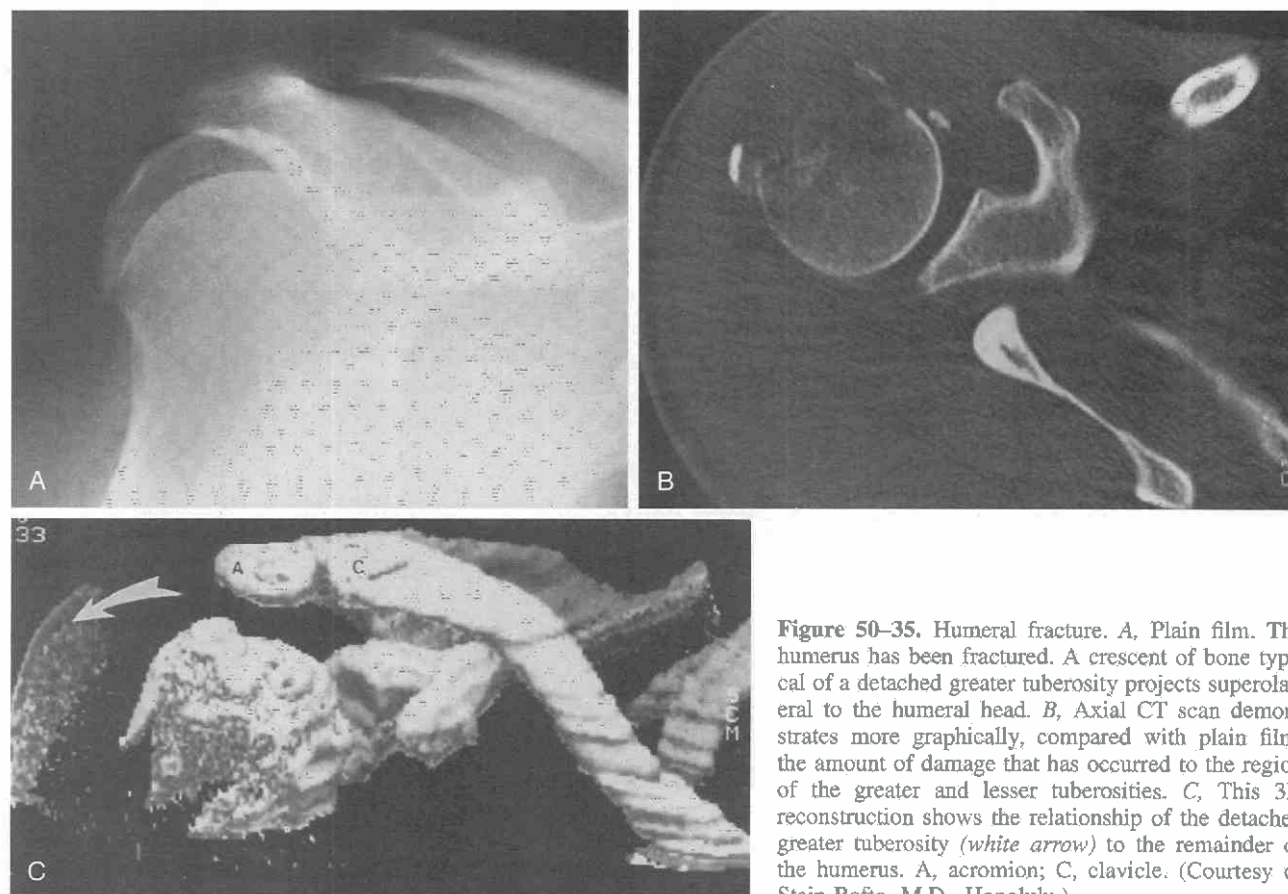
Humeral fracture. A, Plain film. The humerus has been fractured. A crescent of bone typical of a detached greater tuberosity projects superolateral to the humeral head. B, Axial CT scan demonstrates more graphically, compared with plain film, the amount of damage that has occurred to the region of the greater and lesser tuberosities. C, This 3D reconstruction shows the relationship of the detached greater tuberosity (white arrow) to the remainder of the humerus. A, acromion; C, clavicle. (Courtesy of Stein Rafto, M.D., Honolulu.)
